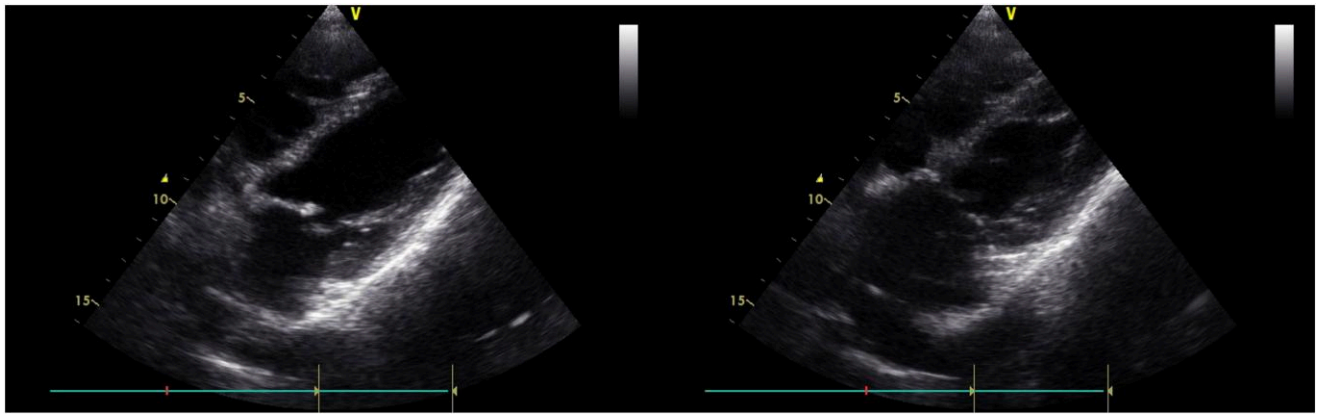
Transthoracic echocardiogram highlighting midventricular segments akinesia with apical compensatory hyperkinesia.
